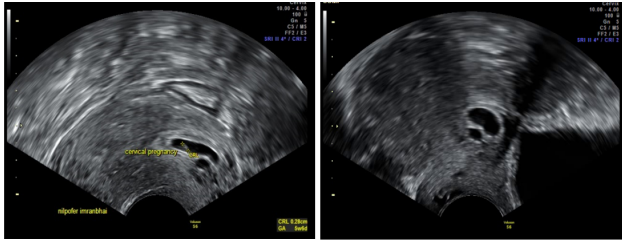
Transvaginal sonography performed on January 6, 2024 (A and B).
